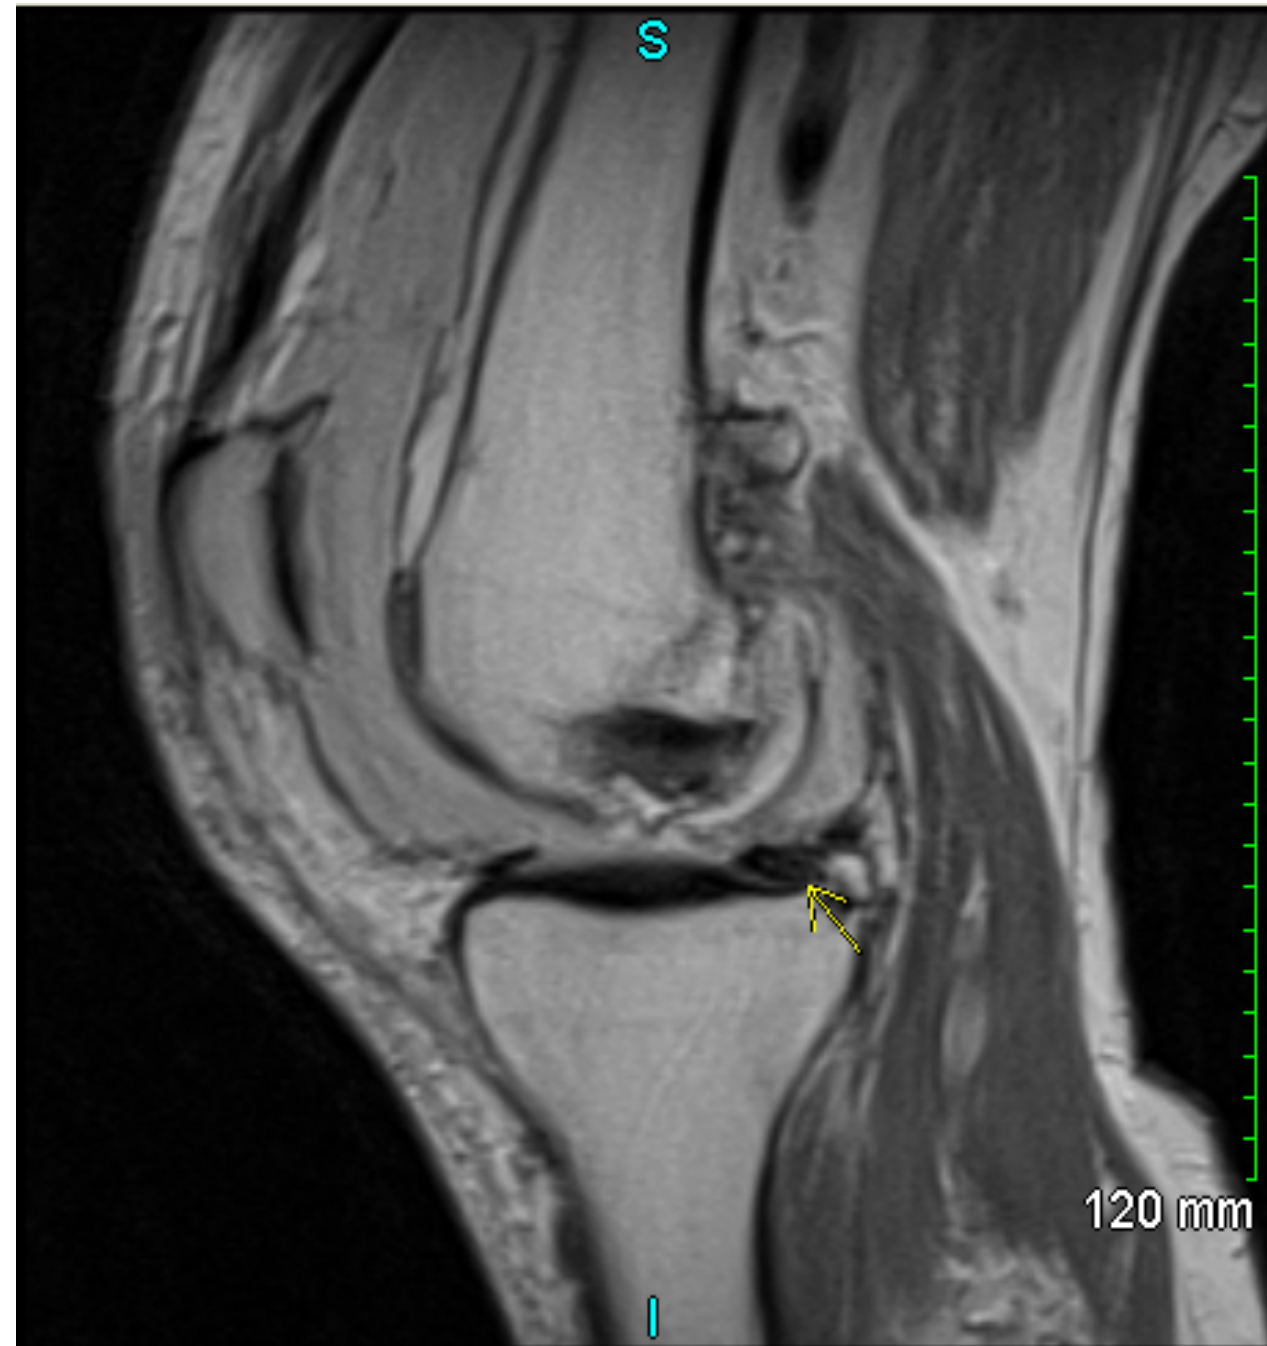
MRI of the right knee showed hemorrhagic effusion 2 weeks after intra-articular injections
